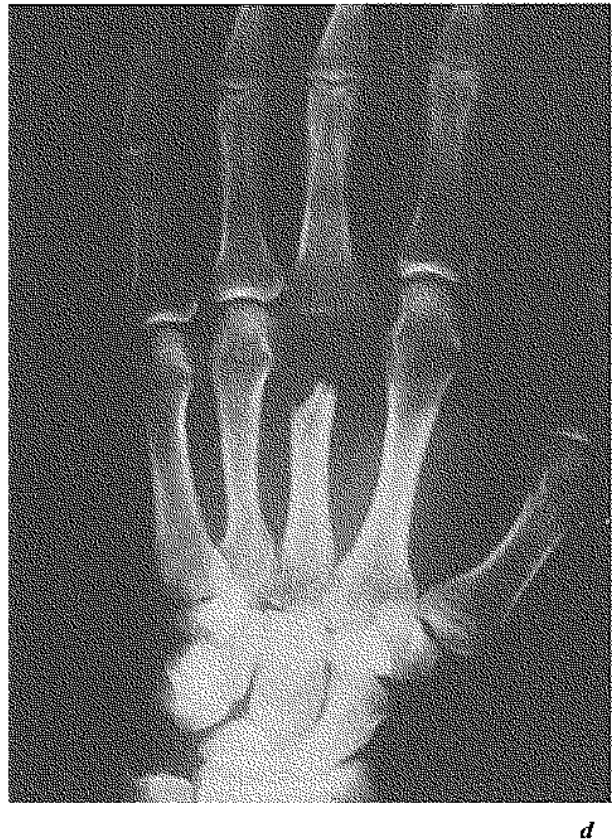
Case 2 — The radiographs on admission (a), 3 weeks later, (b) on presentation in our department ; draining wound, (c) and radiographs (d) 2 months later.
